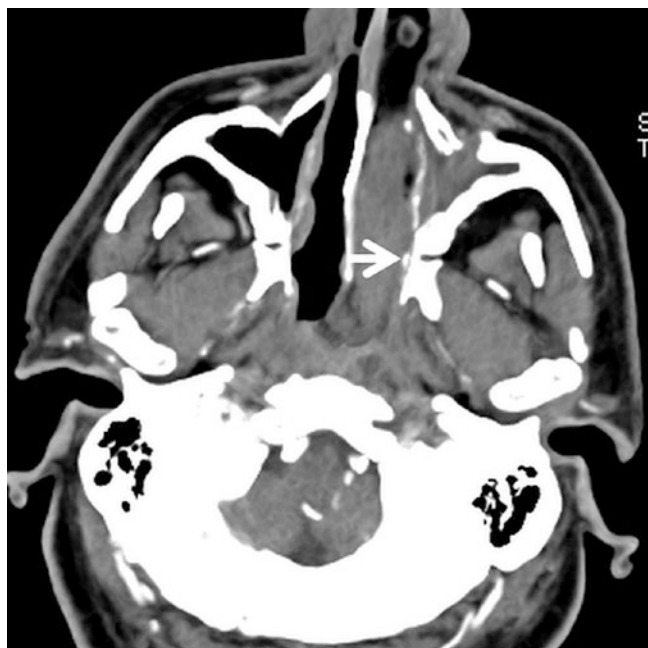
Injury to the sphenopalatine artery. Patient presents with epistaxis after endoscopic polypectomy. CTA demonstrates a focus of active extravasation medial to the sphenopalatine foramen (arrow), consistent with injury to sphenopalatine artery
